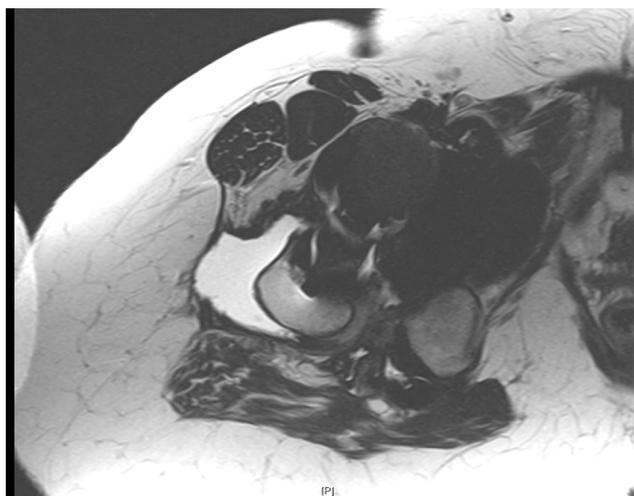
Axial MRI image demonstrating large fluid collection lateral to the greater trochanter and abductor deficiency noted.
